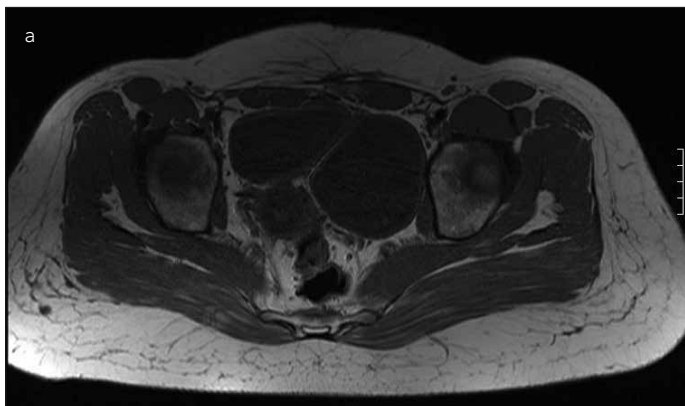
a, b. MRI appearance of incomplete sagittal bladder duplication on a transverse plane (a), MRI appearance of incomplete sagittal bladder duplication on a coronal plane (b)
